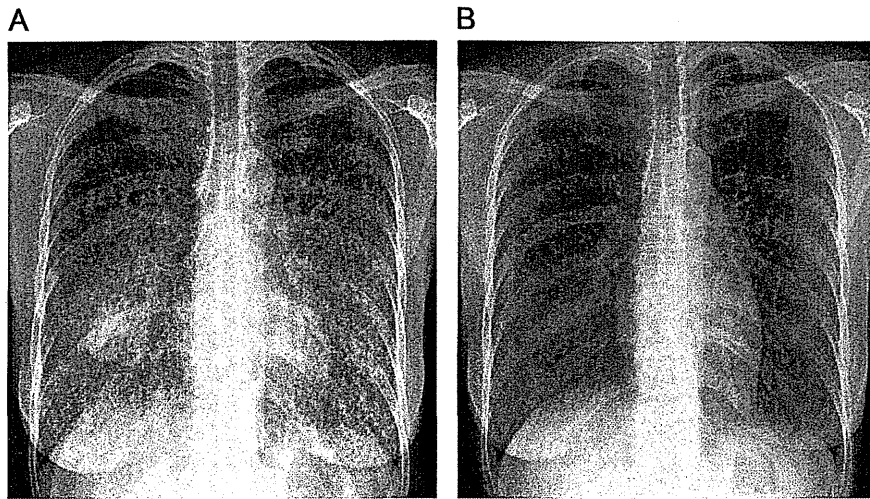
Case 1: Chest radiography. A: Bilateral diffuse granular opacity in the lungs and a mass in the right lower lung field. B: Marked improvement in primary lesion and miliary lung metastases, with disease progression to brain and bone metastases.
